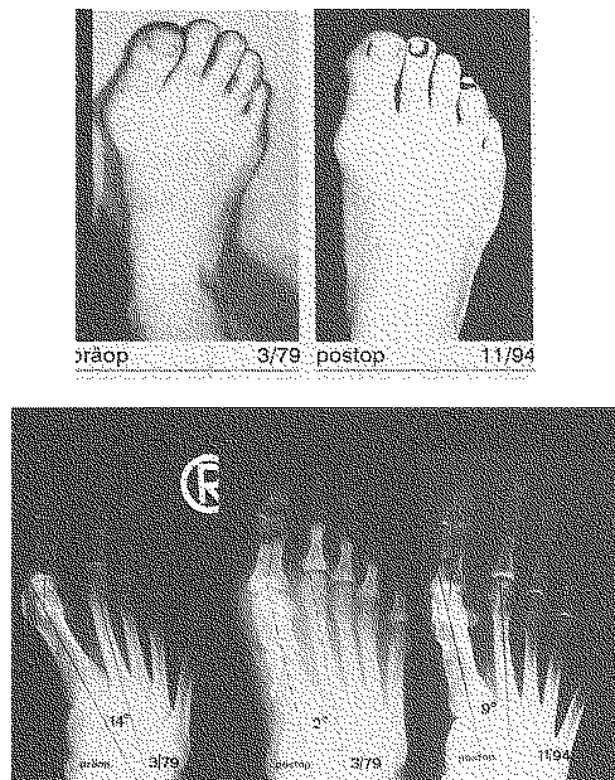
Good result after Mitchell osteotomy : pre- and postoperative clinical appearance and radiographs.
